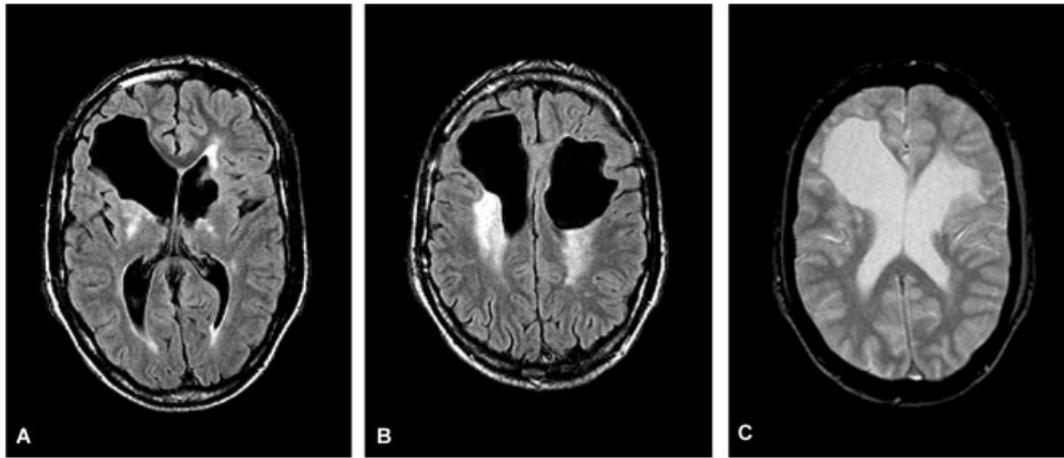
Magnetic resonance imaging of Patient 2 at 33 years old. The axial FLAIR (A, B) show bilateral porencephaly and signal abnormalities in the periventricular (A) and deep (B) cerebral white matter. The gradient-echo images (C) do not show evidence of old small hemorrhages.
